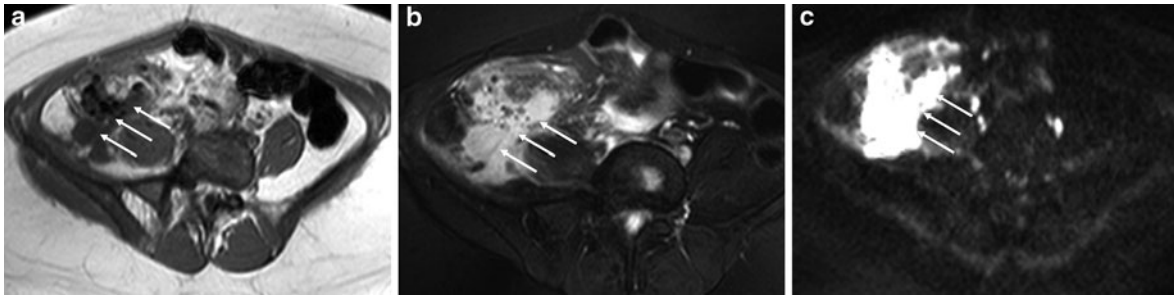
Perforated appendicitis in a 18-year-old pregnant woman. T1-weighted gradient-echo image (a) shows inflammatory mass (arrows) in the right-lower quadrant with low signal intensity. T2-weighted single-shot fast spin-echo image with fat saturation (b) inflammatory mass (arrows) has high
